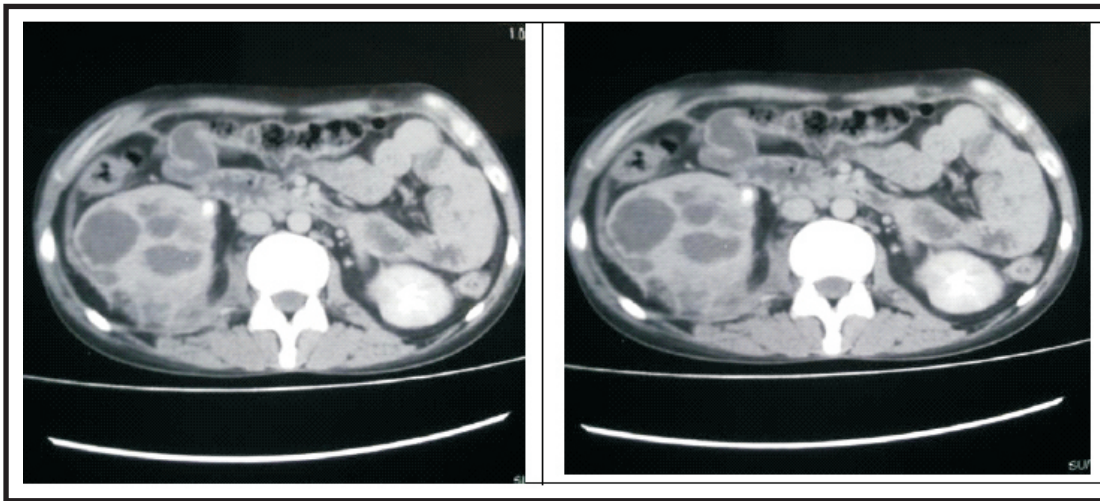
CT scan of the abdomen and pelvis showing paw sign appearance characteristics of Xanthogranulomatous pyelonephritis.
